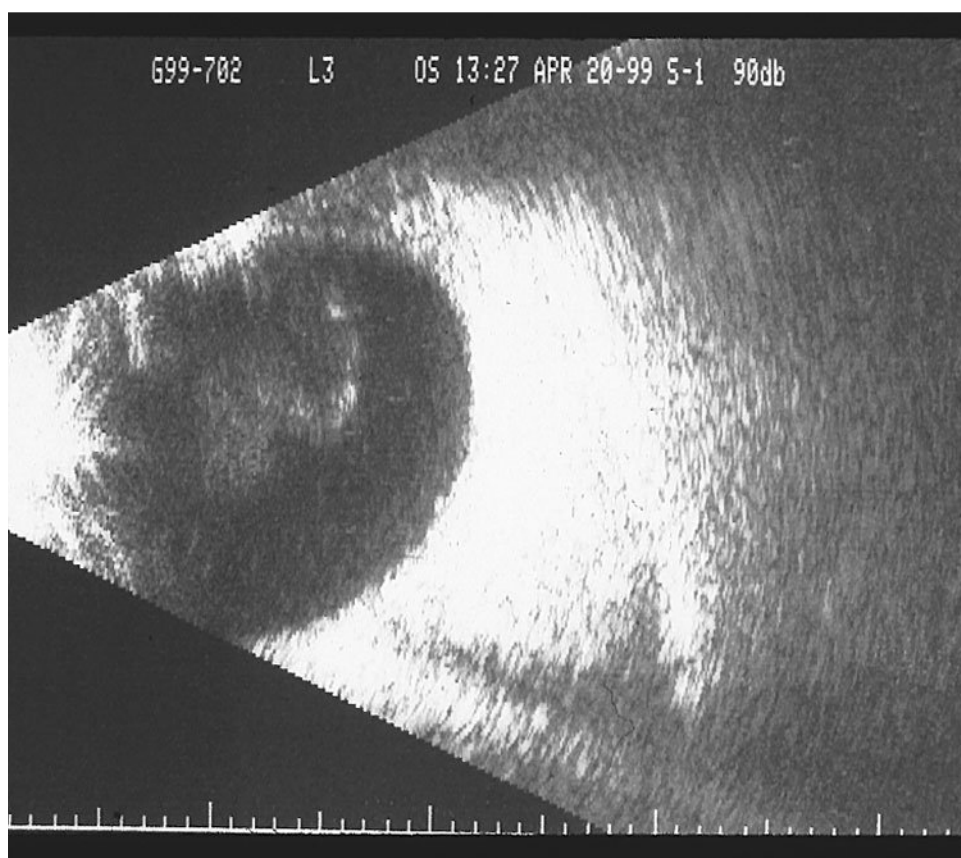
Ultrasonographic appearance showing vitreous opacities and posterior vitreous detachment. No retinal detachment is in evidence. This slice through the macula does not show macular elevation.
